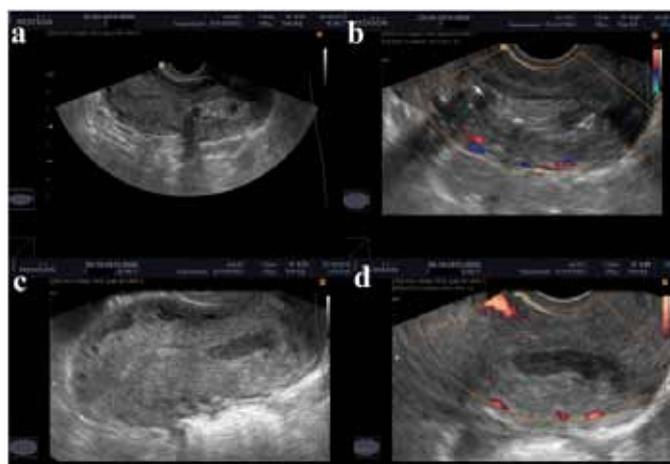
Ultrasound after repeated D&C: (a, b) one day later: cervical canal dilated up to 13 mm with heterogeneous avascular masses volume up to 4 ml; (c, d) 10 days later: volume of hematocervix decreased up to 1 ml.
